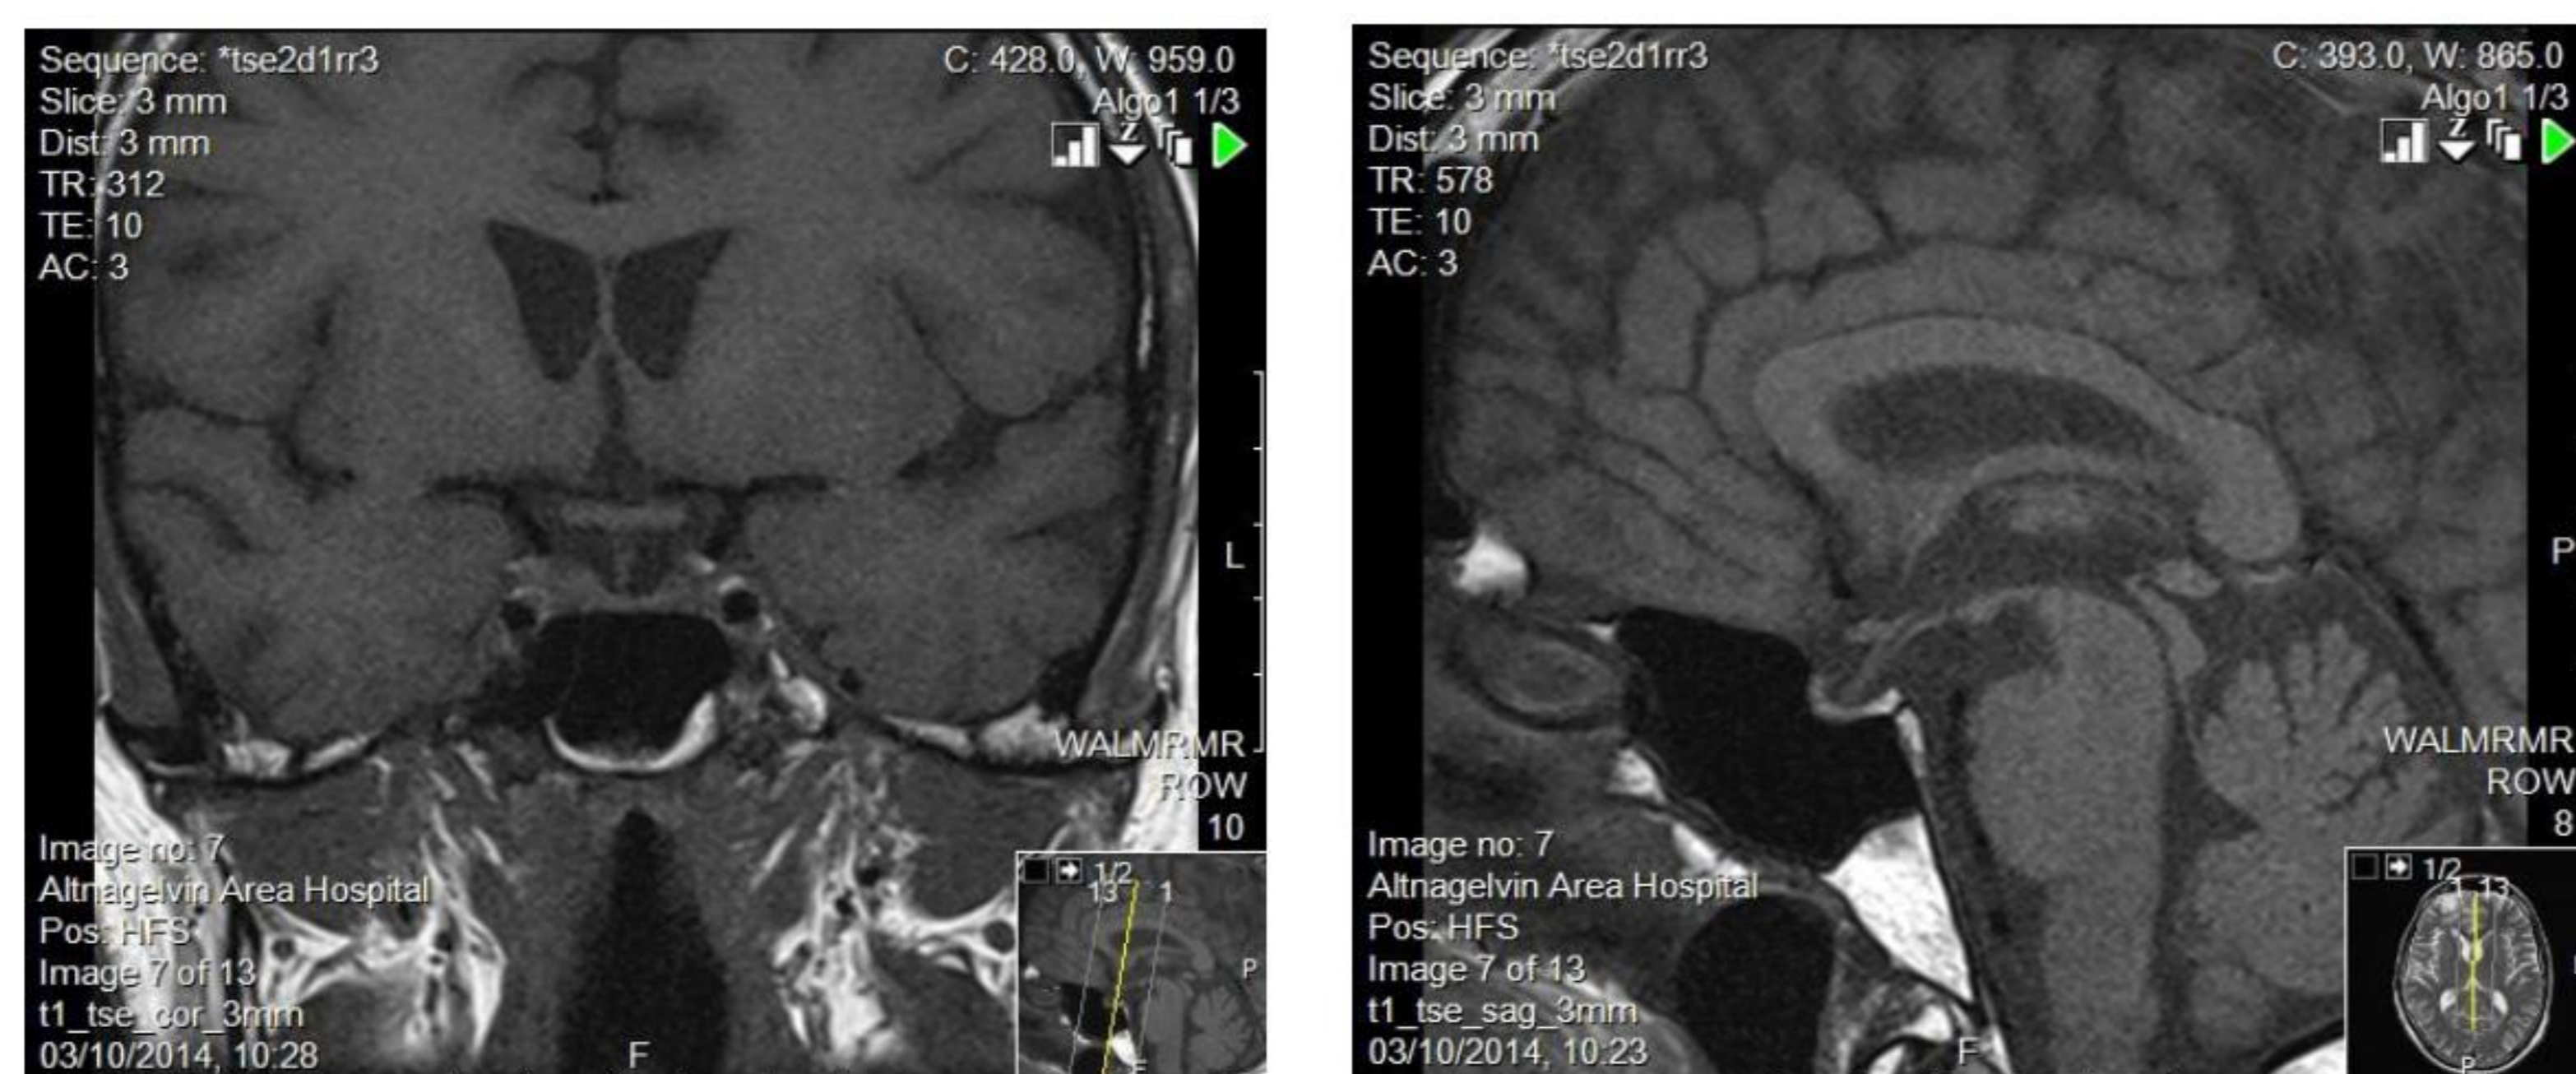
MRI pituitary at time of presentation showing an atrophic pituitary.
